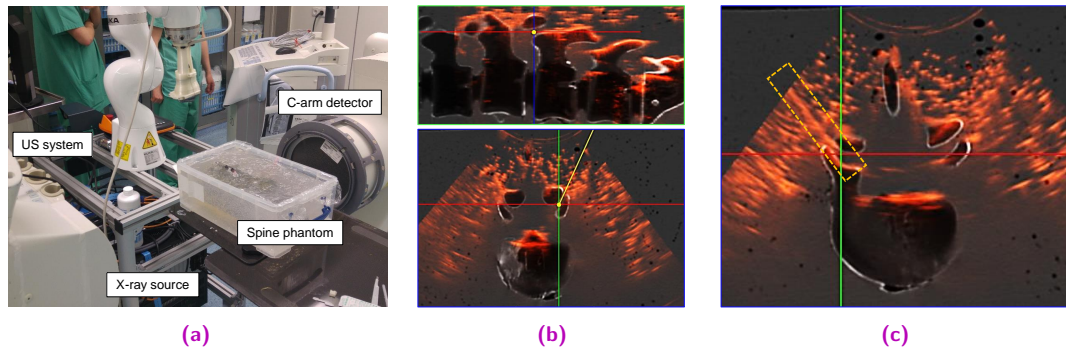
a) Experimental setup in neurosurgery OR. b) Planned needle path shown in sagittal (*top*) and axial (*bottom*) slices of pre-interventional CT (*grayscale*) registered to initial US sweep (*red*). c) The needle can be clearly visualized in US during and after insertion (*yellow box*). Reprint from [249] with permission of Springer.
